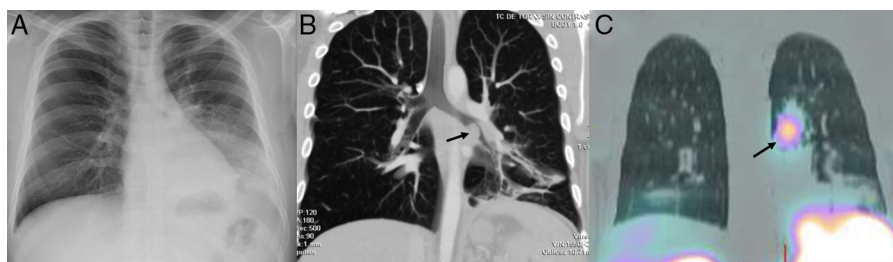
(A) Standard posteroanterior chest X-ray: condensation in left lower lobe (LLL). (B) Coronal computed tomography (CT) with intravenous contrast, volumetric reconstruction: endobronchial mass (arrow) in LLL bronchus with distal pneumonitis and loss of volume. (C) Chest SPECT-CT. Coronal slice: radiotracer hotspot in left parahilar region (arrow).
